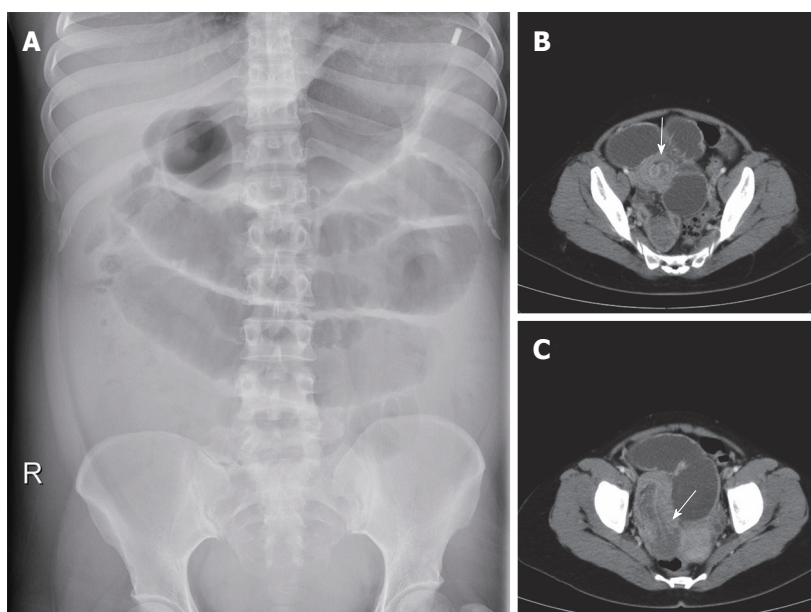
Plain abdominal X-ray revealed dilated small bowel loops. A: Plain abdominal radiograph showing dilated small bowel; B: Abdominal computed tomography showing grossly dilated small bowel loops with “doughnut”; and C: “sausage” signs of small bowel intussusception.
